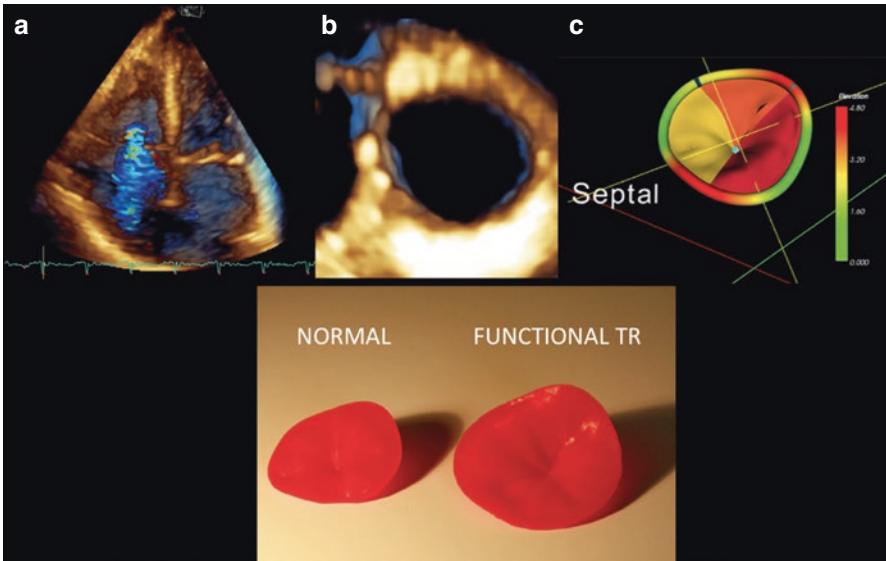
Tricuspid annulus remodelling in severe functional tricuspid regurgitation (TR), as depicted by 3D echocardiography (a–c) and 3D printed models: the annulus becomes larger, rounder and flatter in comparison with normal annulus geometry
